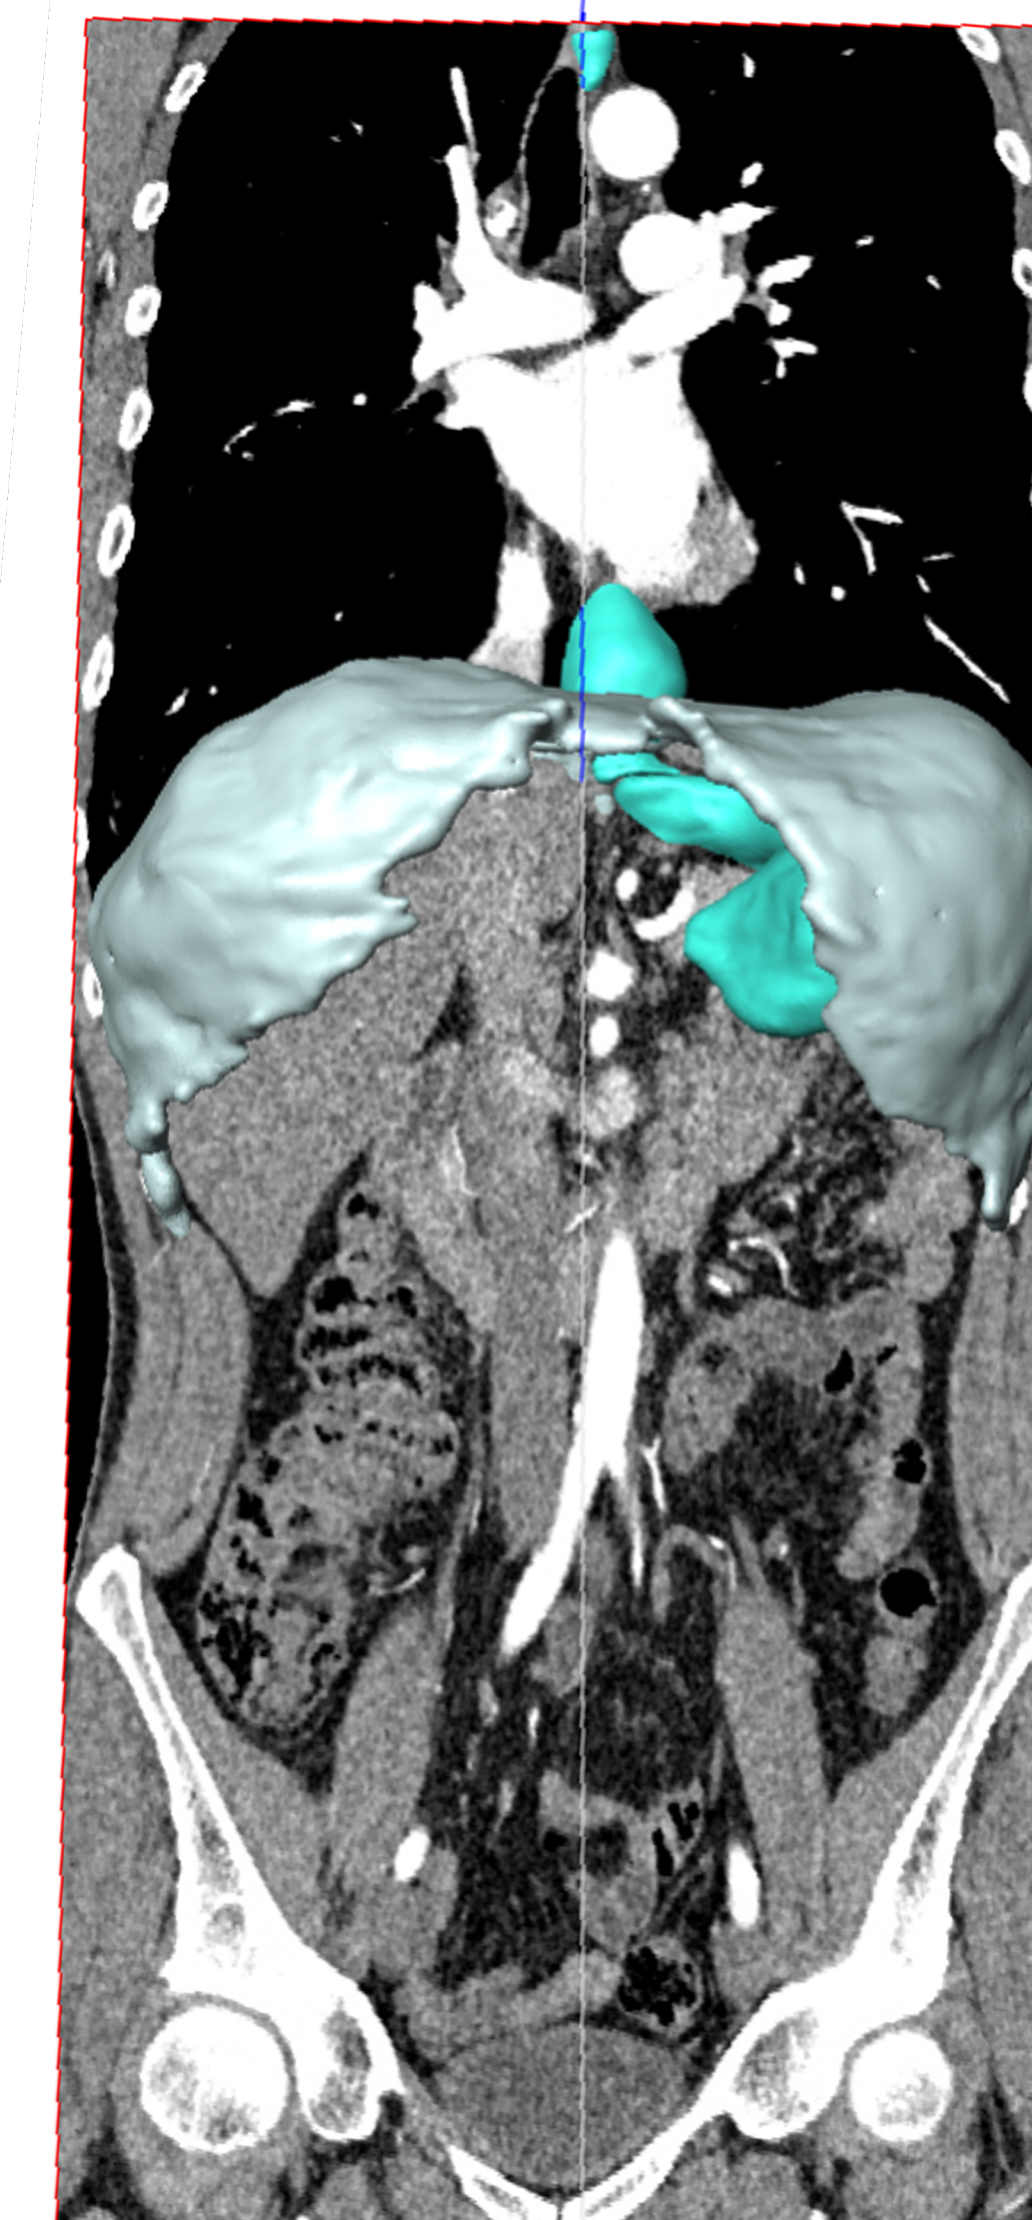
Coronal CT image interposed with 3D-generated anatomical representation of a Type I hiatal hernia
